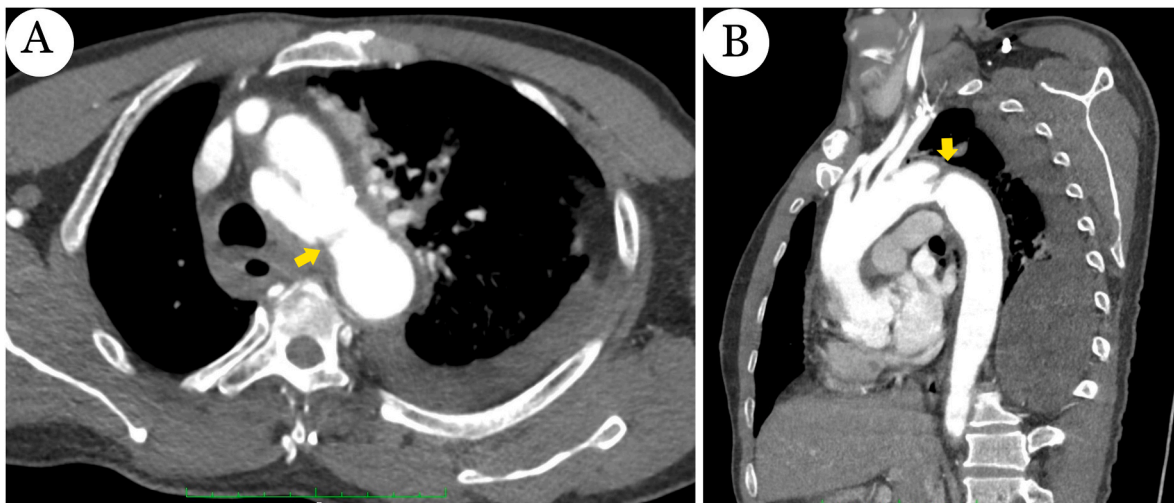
Thoracic aortic rupture with an axial (A) and coronal (B) computed tomography (CT) scan image.
